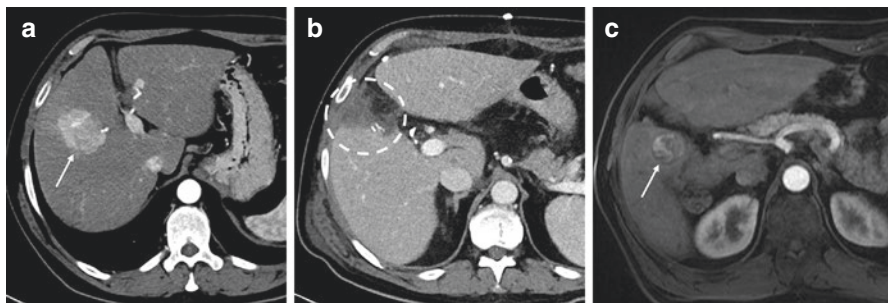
(a) Patient with typical hypervascular hepatocellular carcinoma (HCC) in the right hepatic lobe (arrow) on axial arterial phase contrast-enhanced computed tomography (CT) image. (b) The same patient underwent hepatic resection (circle), as shown on the axial portal venous phase contrast-enhanced CT image performed some weeks after surgery. (c) Six months later, axial contrast-enhanced magnetic resonance imaging in the arterial phase showed recurrent HCC along the hepatic resection margins (arrow)
